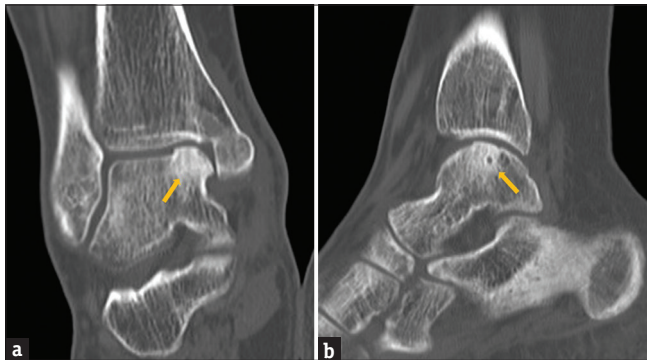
Postoperative 1 year CT revealed adequate bone and cartilage integration (arrow) in (a) AP view and (b) lateral view
